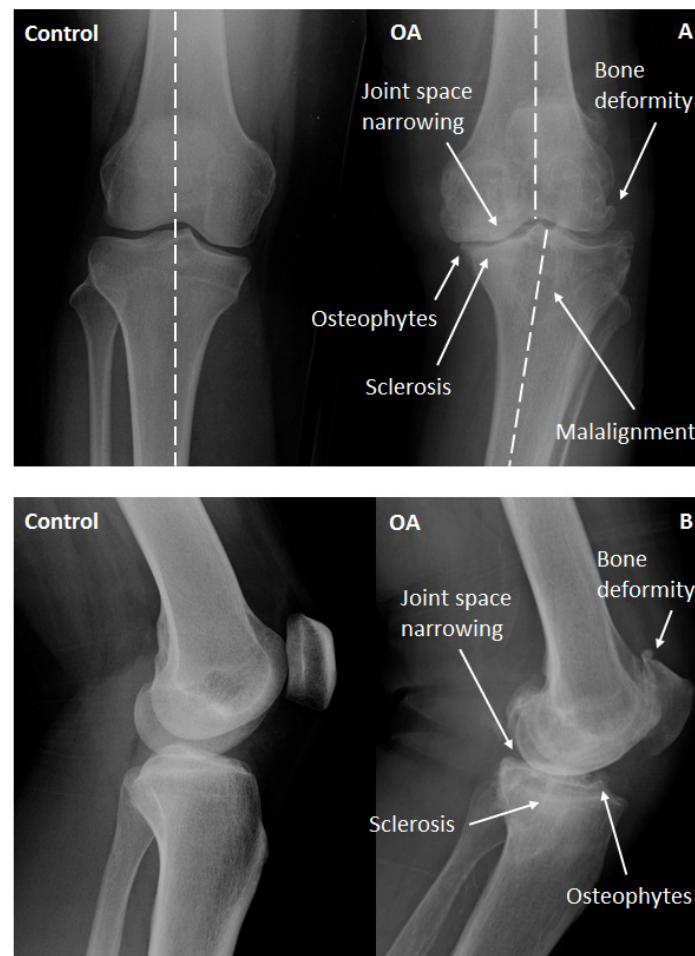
Frontal (A) and lateral (B) radiographs of healthy (Control) and Kellgren-Lawrence (KL) grade 4 osteoarthritic knees (OA). Radiographs of the osteoarthritic knees evidence the presence of osteophytes, joint space narrowing, sclerosis and bony deformities. In the osteoarthritic knee frontal scan, the presence of misalignment is also detected (Images supplied by Doctor Acácio Ramos).
